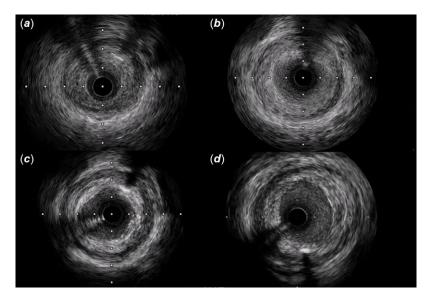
Intravascular ultrasound images before and after catheter intervention. (*a*) Intravascular ultrasound (IVUS) image of the stenotic lesion in the proximal left anterior descending coronary artery (LAD) showed an eccentrically fibrous intimal thickening with homogeneous high intensity before percutaneous coronary intervention (minimal lumen area was 2.59 mm<sup>2</sup>). (*b*) IVUS image at the stenosis site after the cutting balloon angioplasty (minimal lumen area was 6.48 mm<sup>2</sup>). (*c*) IVUS image at the stenosis site after the drug-coated balloon angioplasty (minimal lumen area was 6.52 mm<sup>2</sup>). (*d*) IVUS image at the stenosis site 6 months later (minimal lumen area was 6.84 mm<sup>2</sup>).
